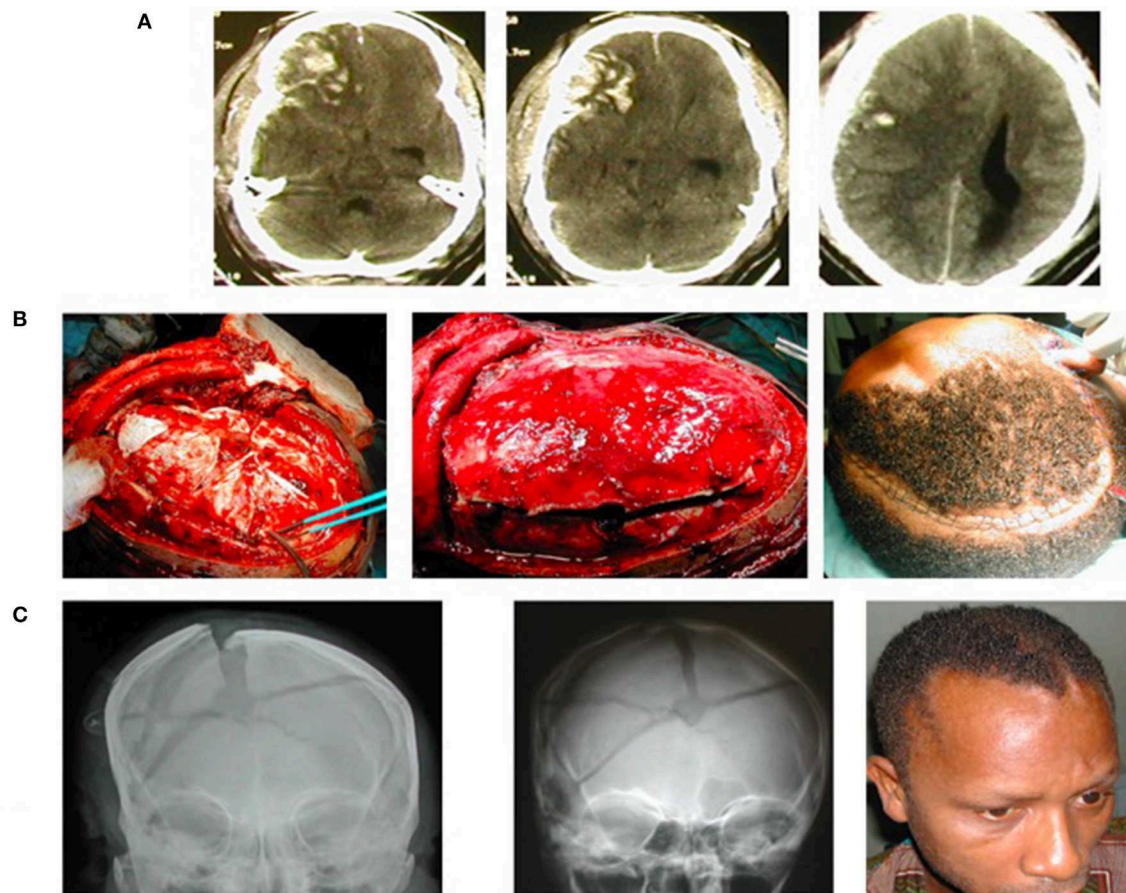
A young man suffered severe traumatic brain injury (TBI), GCS7/15, from road trauma. (A) Cranial CT showed right-sided brain contusions, acute subdural hematoma, subarachnoid hemorrhage, intracerebral hematoma, and bilateral brain swelling that was worse to the right—CT Rotterdam of 6. (B) Intraoperative image of the hinge craniotomy, cruciate durotomy, and evacuation of the extra-axial bleed (to the left); the bone flap returned, floating *in situ* (middle); and skin closure (to the right). (C) Plain skull X-ray on the first postoperative day showing the elevated/floating bone flap (to the left), bone also revealed comminuted skull fracture; Plain skull X-ray (middle) and clinical picture of the patient (right) 5 weeks postop showing the bone flap spontaneously returned to the rest of the cranium following resolution of the traumatic brain swelling.
